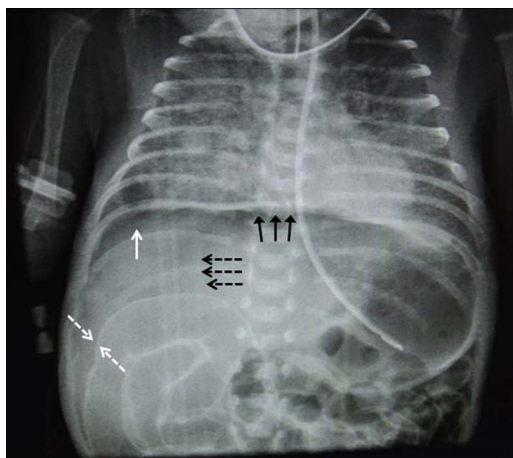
Supine radiograph of the chest including the upper part of the abdomen showing the presence of free intraperitoneal gas as evidenced by the outlining of the falciform ligament (dashed black arrows), the presence of air on both sides of the bowel wall (dashed white arrows), known as Rigler's sign, subdiaphragmatic air in the right upper quadrant (solid white arrow) and cupola sign showing air within the median subphrenic space (solid black arrows).
